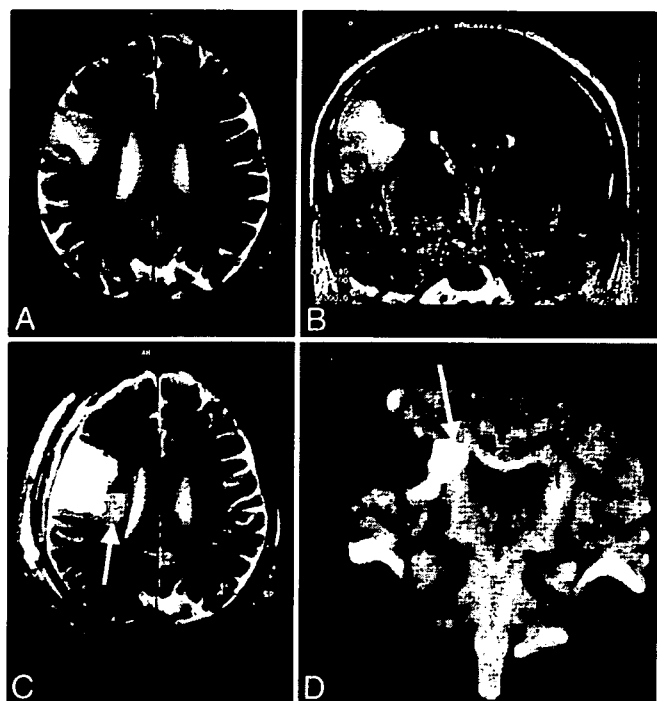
Case 3. Images obtained in a 68-year-old man with an anaplastic astrocytoma in the right tongue sensorimotor area. Preoperative axial T₂-weighted (A) and coronal fluid-attenuated inversion-recovery (B) MR images revealing a high-intensity mass in the right frontoparietal opercular region. Postoperative axial T₂-weighted (C) and coronal DW (D) MR images showing total removal of the tumor and a new high-intensity lesion (arrows) beneath the resection cavity. The lesion extends to the region of the corona radiata, probably involving the corticospinal tract. This tract appears as a bandlike area of slightly high intensity on the coronal DW image with the motion-probing gradient applied only in the anteroposterior direction.
